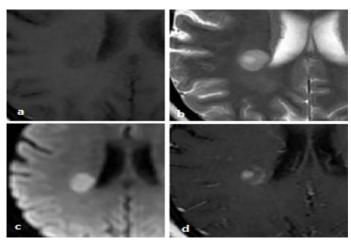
The right frontoparietal lesion is iso/hypointense on T1-weighted (a), iso/hyperintense on T2-weighted (b), hyperintense on diffusion weighted (c) images, and its T2-hyperintens areas show enhancement after gadolinium administration (d).
